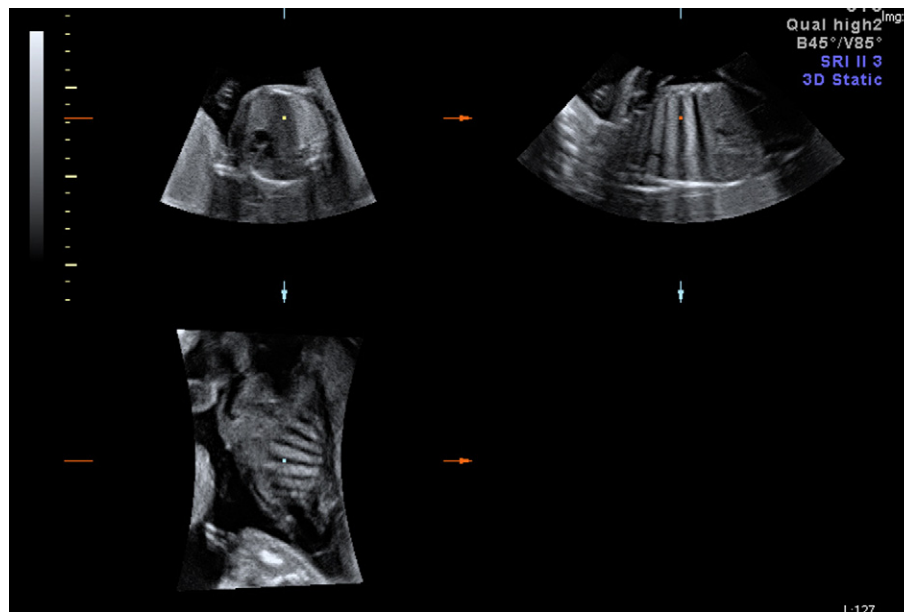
Prenatal 3-D ultrasound (multiplanar orthogonal view) of CCAML type III at 21 weeks of gestation (the same case as in Fig. 1).
